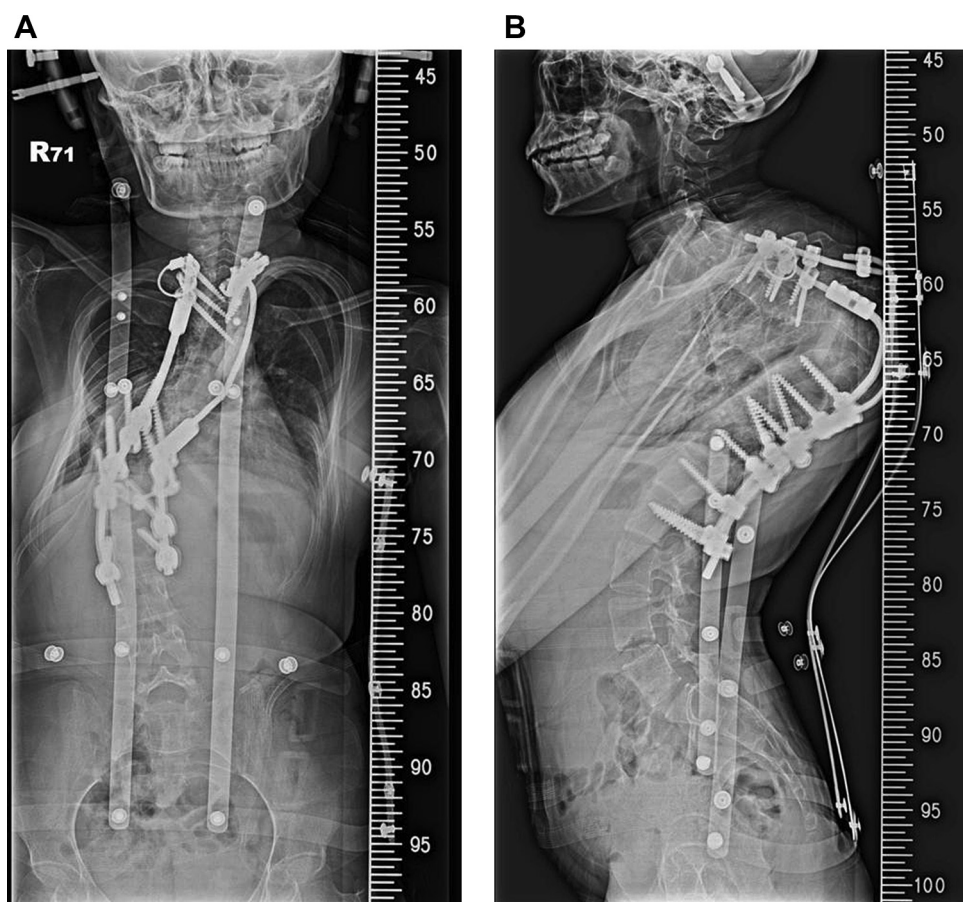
Postoperative (final stage) radiography of the 16-year-old girl: (A) anterior–posterior view and (B) lateral view.
